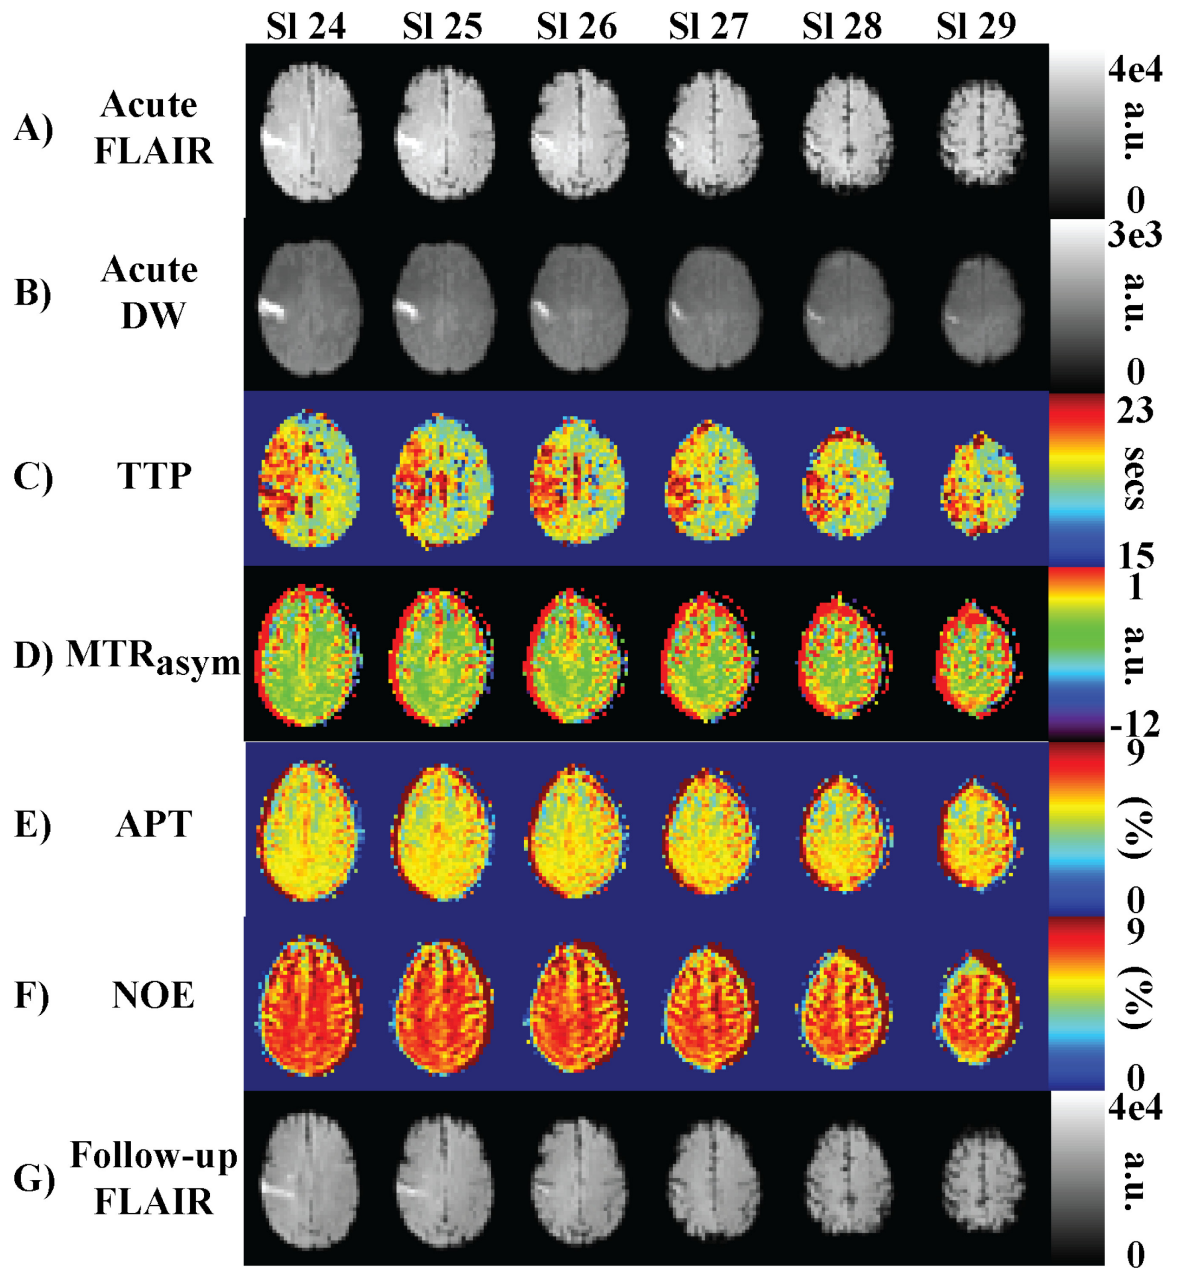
Slices 24 to 29 for Patient 2. (A) Acute FLAIR scan. (B) Acute mean diffusion weighted image. (C) Time-to-peak image. (D) MTR<sub>asymmetry</sub>(3.5 ppm). (E) APT. (F) NOE (G) Follow-up FLAIR.
